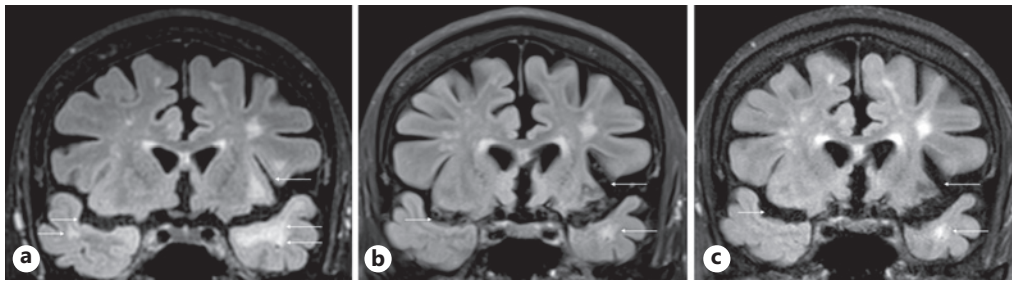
Coronal FLAIR sequences show a hypersignal in the left and right temporal lobes as well as a cortico-subcortical atrophy of both temporal lobes, which are subtle in the baseline MRI (a) and increase on a 13-month (b) and a 21-month (c) follow-up MRI.
